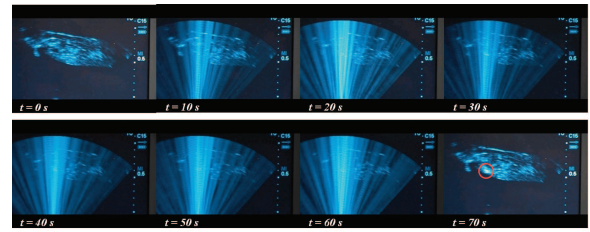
Ultrasound visualization of HIFU activity. Snapshots at 10 (sec) intervals. Sonicated area appears bright due to cavitation (red circle).
